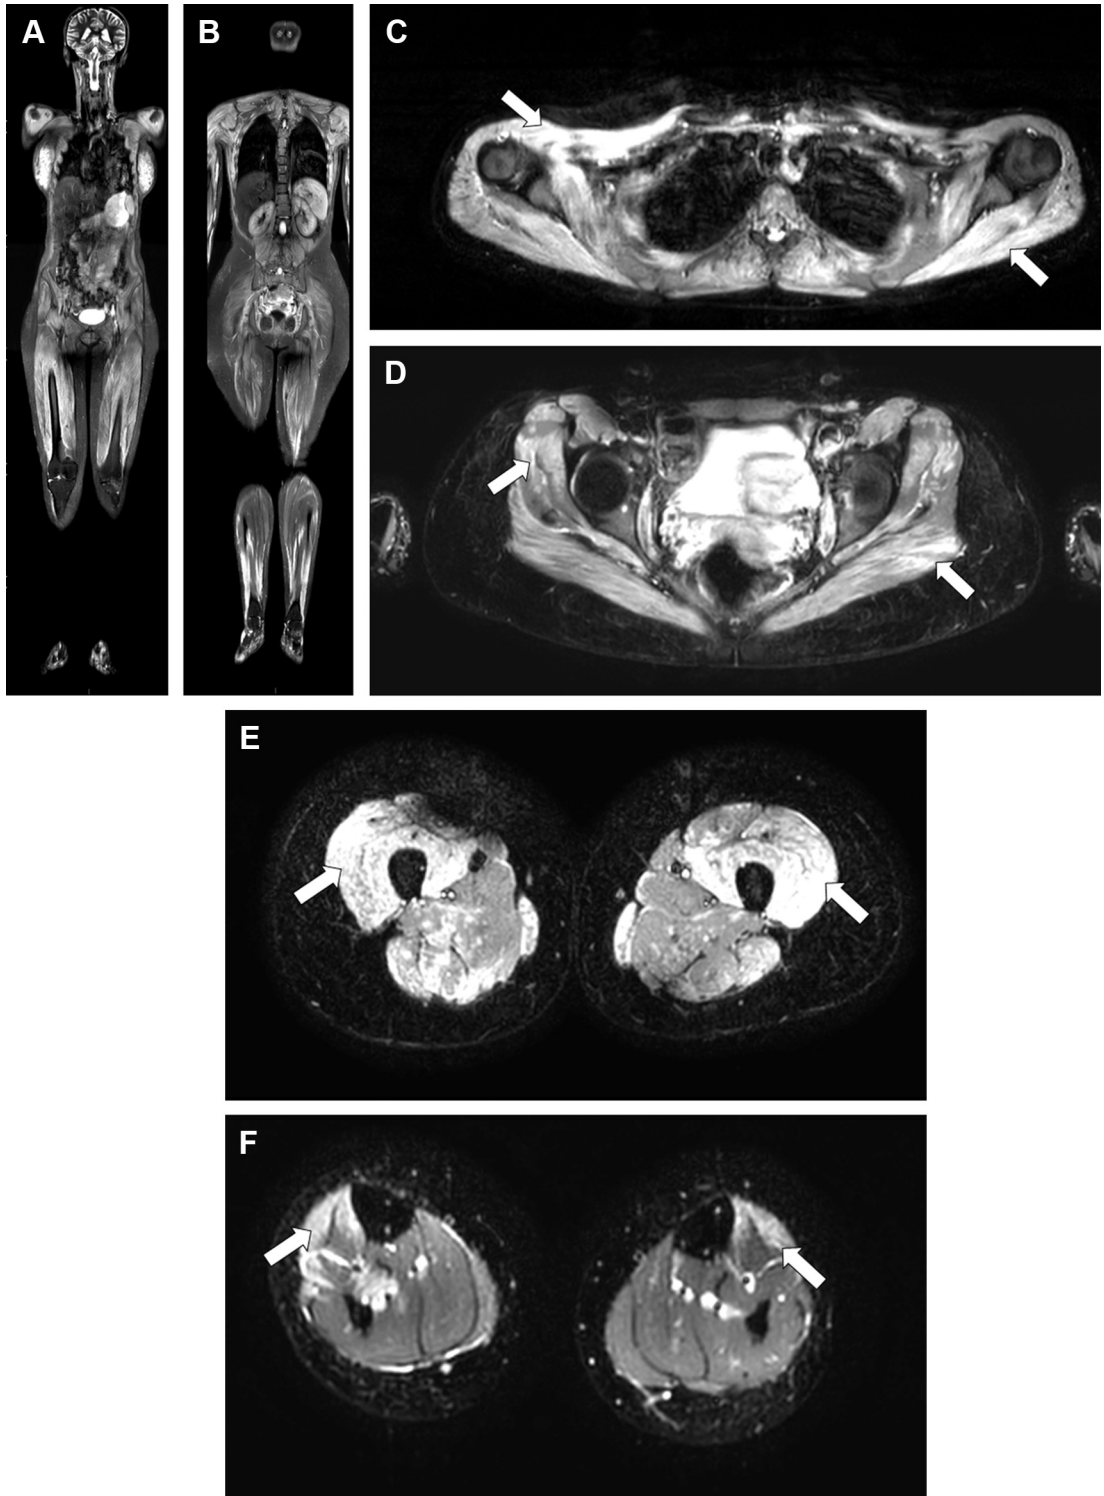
WB MR imaging from a 26-year-old woman with diffuse muscle pain and increased serum creatine kinase level showing multifocal muscle abnormalities. Coronal (A, B) and transverse (C–F) STIR MR imaging shows severe multifocal (almost diffuse) abnormal signal intensity areas (arrows) involving the muscles in the upper and lower limbs. Dermatomyositis with autoantibodies was diagnosed after biopsy of an involved muscle (note the absence of evident subcutaneous tissue abnormalities on WB MR imaging). Corresponding coronal (G, H) and transverse (I–L) MR imaging after a 3-month treatment with high doses of glucocorticoids and methotrexate shows an almost complete disappearance of the muscle abnormalities.
